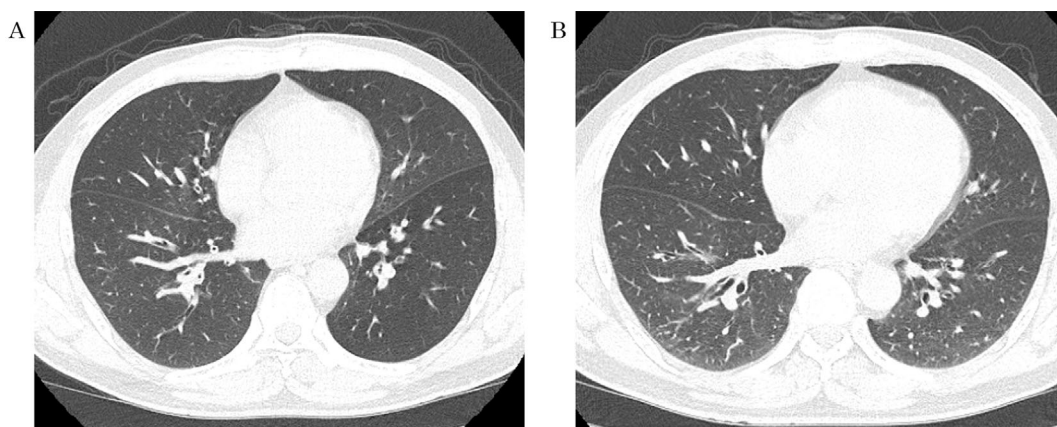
Chest CT scans in a patient with severe persistent asthma. Before BT, there was substantial bronchial wall thickness and air trapping in the expiratory phase (A). After BT, there was significant improvement in these findings (B). CT: computed tomography, BT: bronchial thermoplasty
